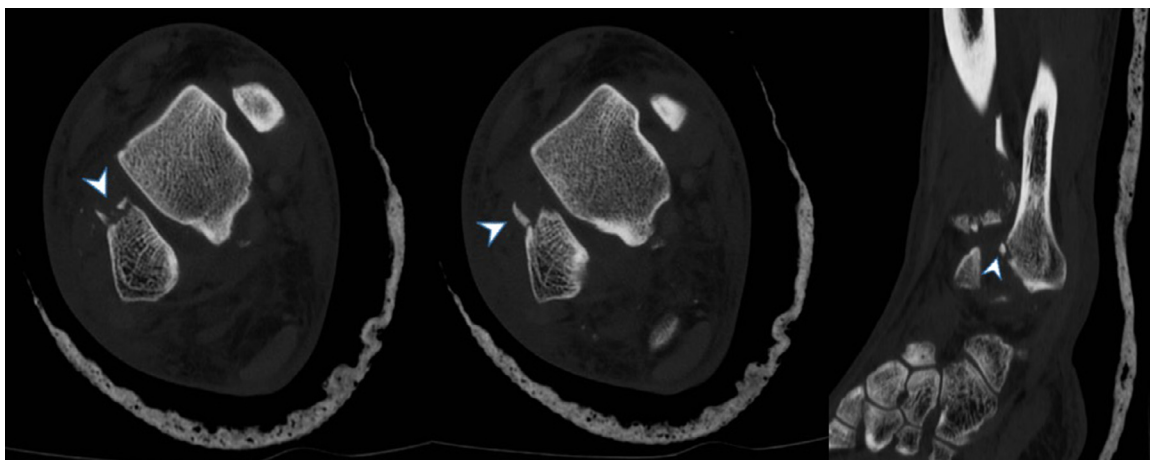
Preoperative computed tomography scan showing the fragmentation of the anterior tubercle of the distal fibula (arrowhead), axial and sagittal views.
